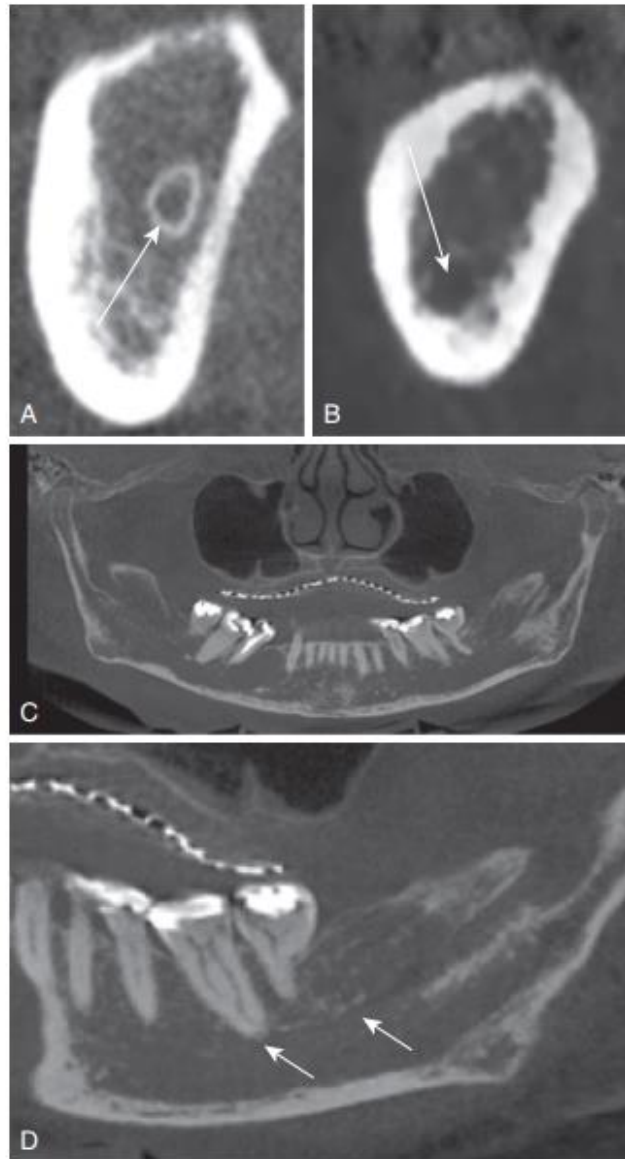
(A) The mandibular canal (*arrow*) is easily seen when a thick cortical component is present. (B) However, in 30% of patients, the mandibular canal will not have a cortical component (*arrow*). (C) CBCT panoramic view depicting thin cortical outline with poorly defined internal bony trabecular pattern indicative of osteoporosis/osteopenia. (D) Poorly defined mandibular canal (*arrows*).
